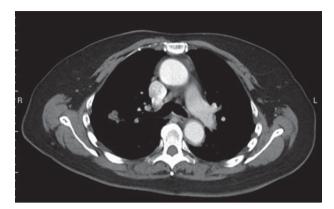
Computed tomography (CT) of the chest showed a lobulated soft tissue nodule about 1.6 cm in size at right upper lobe (RUL) which was highly suspicious of bronchogenic cancer and several soft tissue nodules in the lower mediastinum, PTRC space, and prevascular region (maximal short axis: about 1-cm) which were considered as malignant lymphadenopathy. No other small pulmonary lesion could be detected.
